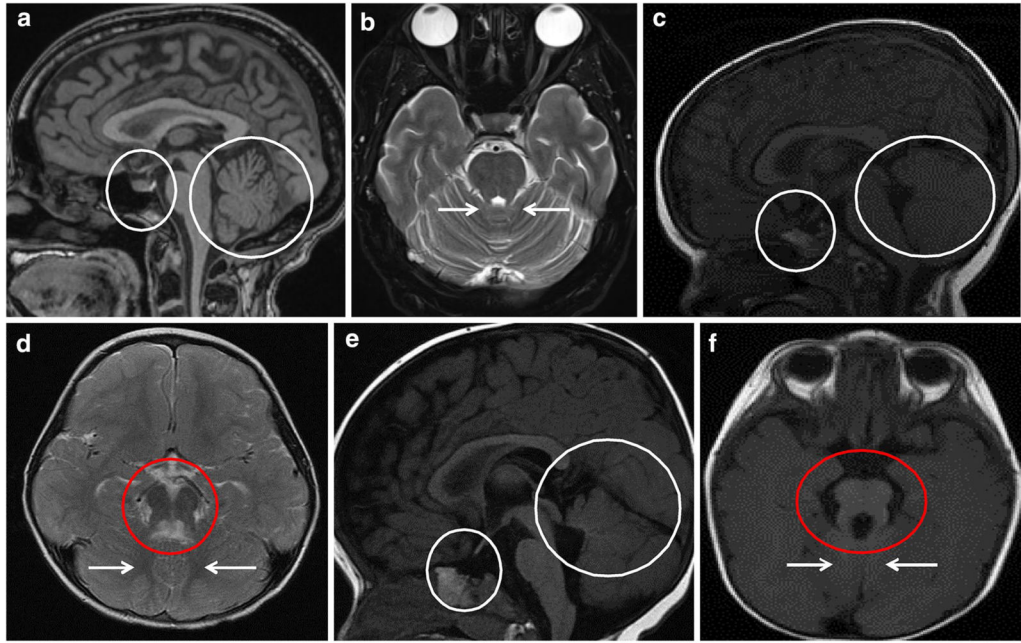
Brain MRI images of patients 1 and 2 in comparison to normal. a Sagittal T1-weighted and b axial T2-weighted brain MRI images of healthy controls showing normal appearance of pituitary gland (*small circle*) and cerebellar vermis (*large circle*), and superior cerebellar peduncles (*arrows*). c–f Both patients had cerebellar vermis hypoplasia (*large circles*), dysplastic vermis (*arrows*) and thickened and horizontally oriented superior cerebellar peduncles resulting in the appearance of “molar tooth sign” on axial MRI images (*red circles*). c Patient 1 had an ectopic posterior pituitary gland (*small circle*). c Patient 2’s pituitary stalk appeared to be absent and the pituitary gland itself was very small (*small circle*). There was a suggestion of a pituitary bright spot immediately posterior to the chiasm, suggesting an ectopic posterior pituitary
